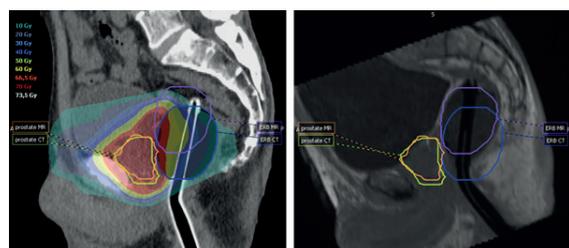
CT and MR images with dose overlay and delineations for worst-case deviation in ERB insertion depth.
